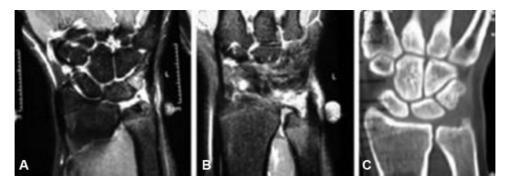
Magnetic resonance and computed tomography imaging from a female patient previously submitted to a surgery at the triangular fibrocartilage complex (TFCC). She still complains of pain the ulnar border of the carpus.⁴¹ (A) magnetic resonance imaging shows synovitis and lunate and triquetrum edema; (B) the lesion affects only the distal portion of the triangular fibrocartilage; (C) computed tomography scan shows a neutral ulna.
